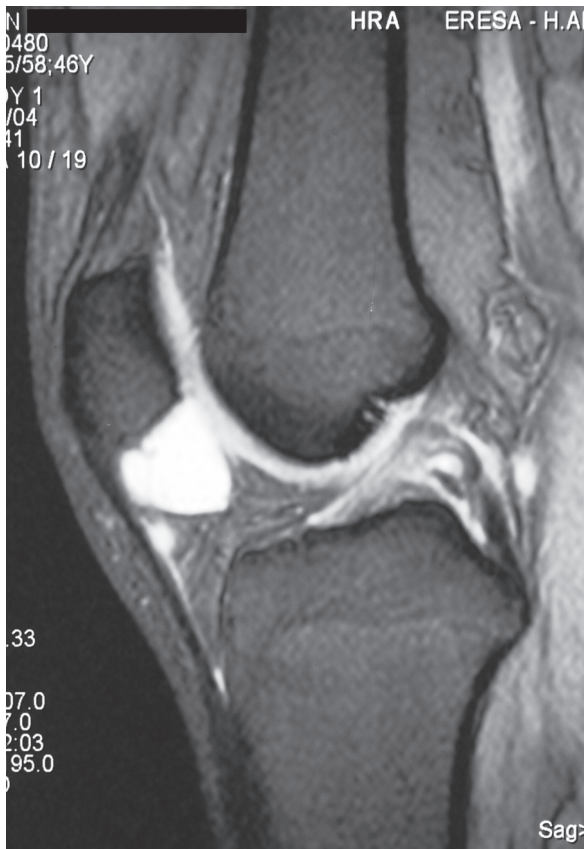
Sagittal FSE PDW Fat Sat MRI showing an intra-articular ganglion cyst in the Hoffa's fat pad
